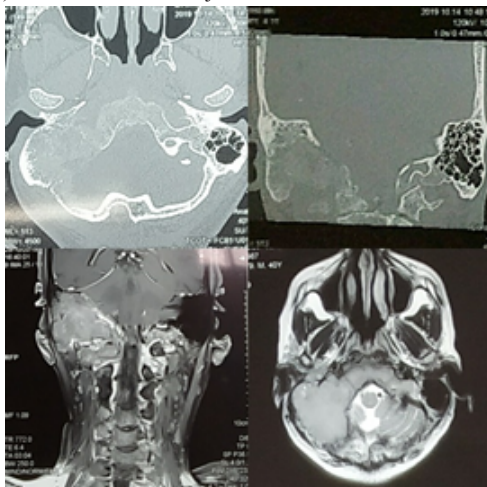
CT Brain showed ill-defined osteolytic lesion involving Rt.temporal base and basiocciput. On MRI Brain, found to be T2 isointense and heterogenous contrast enhancing lesion .
